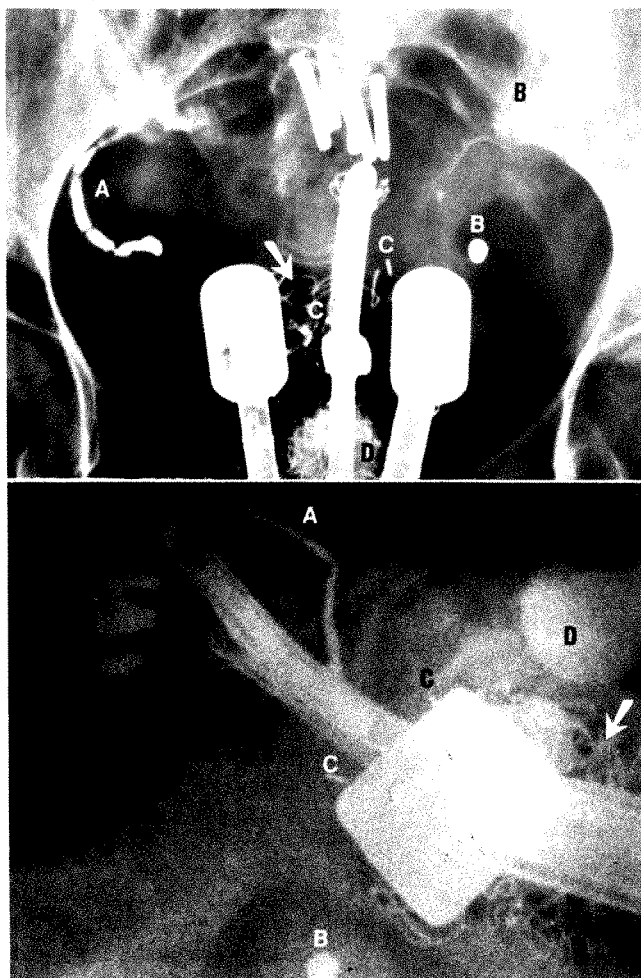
Roentgenograms of representative intracavitary implant. Note residual barium in appendix (A) and sigmoid diverticula (B), cervix as indicated by submucosally placed gold seeds (C), bladder neck as demarcated by contrast medium in bulb of Foley catheter (D), and radiopaque marker in vaginal packing (arrow).
